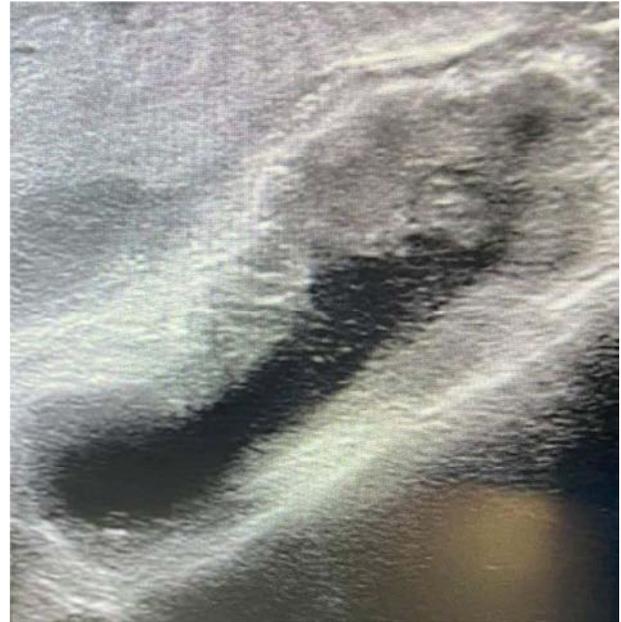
Intra-operative ultrasound.
